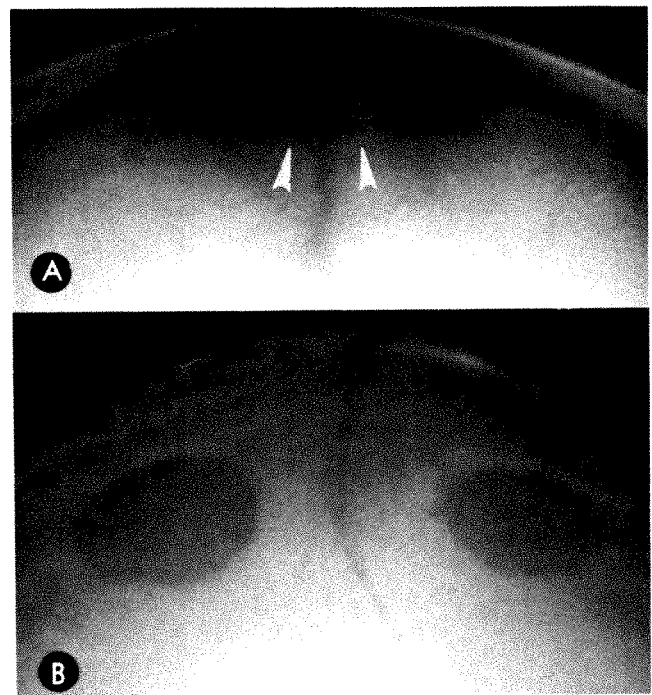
Frontal roentgenograms in two children aged 8 months (*A*) and 2½ years (*B*) with large parietal foramina. Foramina still bridged by a non-ossified stripe to sagittal suture in 8-month-old (arrows).
